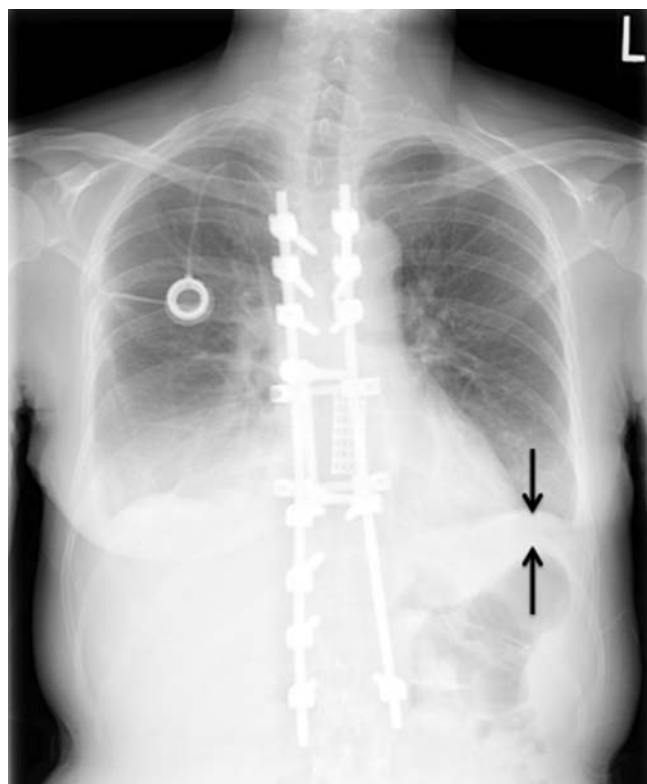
Posteroanterior chest radiograph of a patient with bilateral pleural effusion reveals increased separation between the left lung and subdiaphragmatic gas (arrows).
